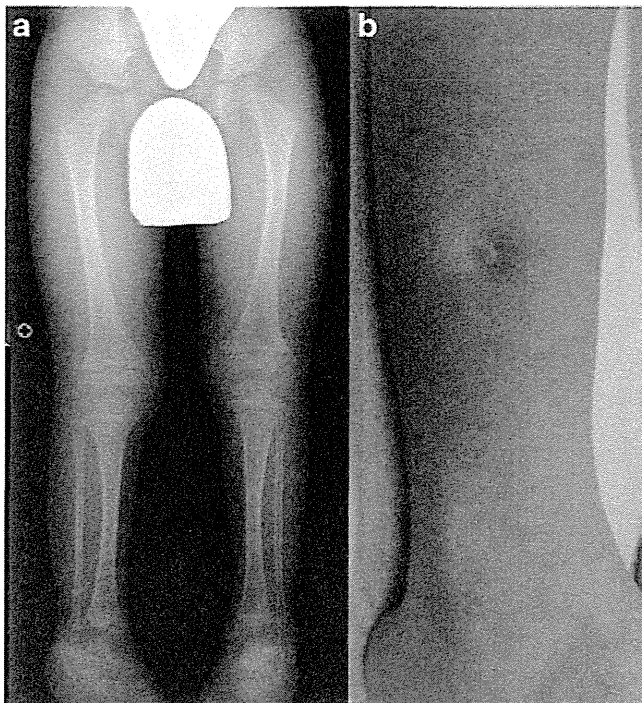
A 5-year-old boy with prenatal hypophosphatasia. a Anteroposterior radiograph of the lower limbs shows improvement of the long bone bowing and disappearance of bilateral fibular spurs. b Clinical photo of the right lower limb demonstrates a residual skin dimple
